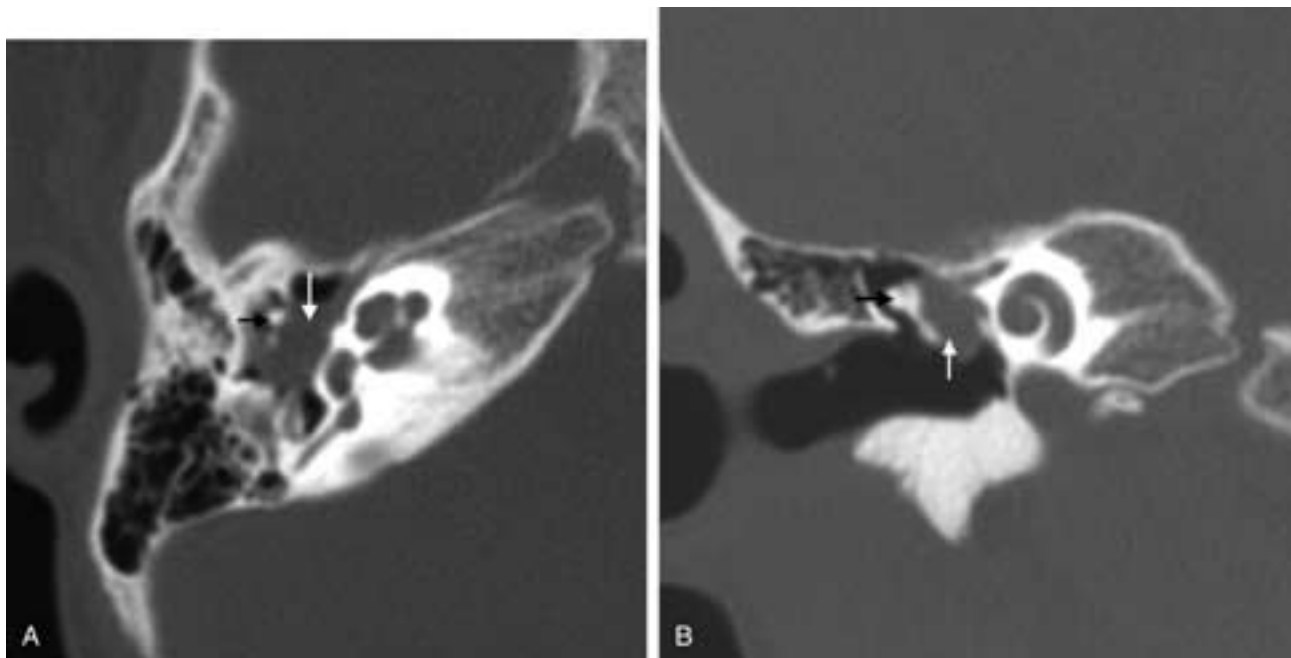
Congenital cholesteatoma of the middle ear without EAC atresia. Axial CT (A) and coronal CT (B) images showing a lobulated soft-tissue mass (white arrows) within the middle ear cavity medial to the ossicular chain (black arrows) consistent with congenital cholesteatoma.
